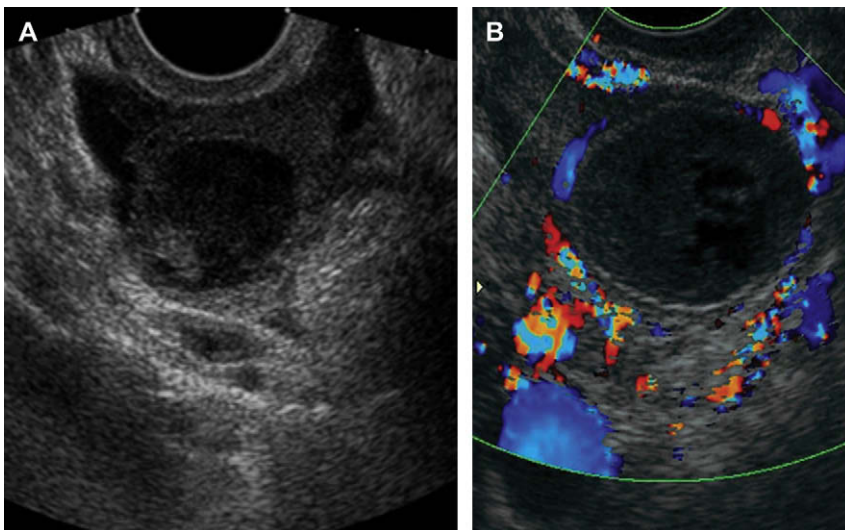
Corpus luteum cyst. (A) Transvaginal grayscale image of the left ovary demonstrates a cyst with debris within, suggestive of hemorrhage in a corpus luteum cyst. (Courtesy of A. Khurana, MD, India). (B) Corresponding color flow Doppler image demonstrates peripheral vascularity—called the “ring of fire.”
